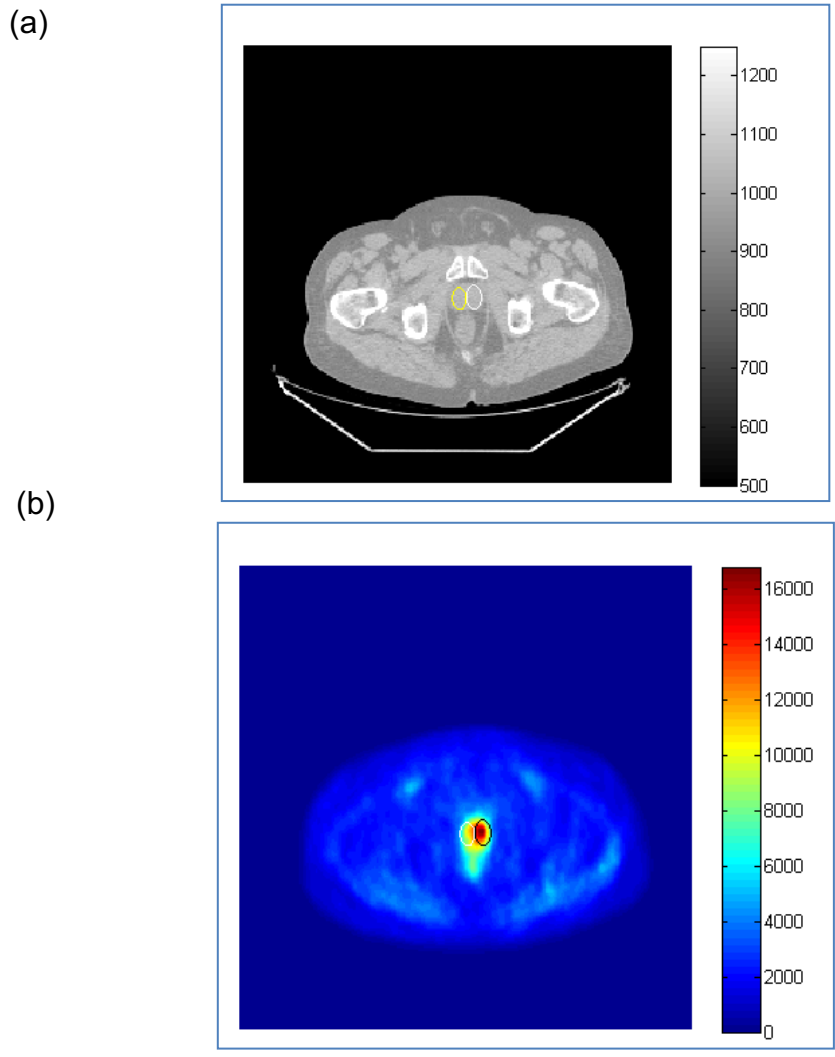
Axial Low dose CT and axial PET images of the pelvis. Regions of interest were drawn on both lobes of the prostate gland.
